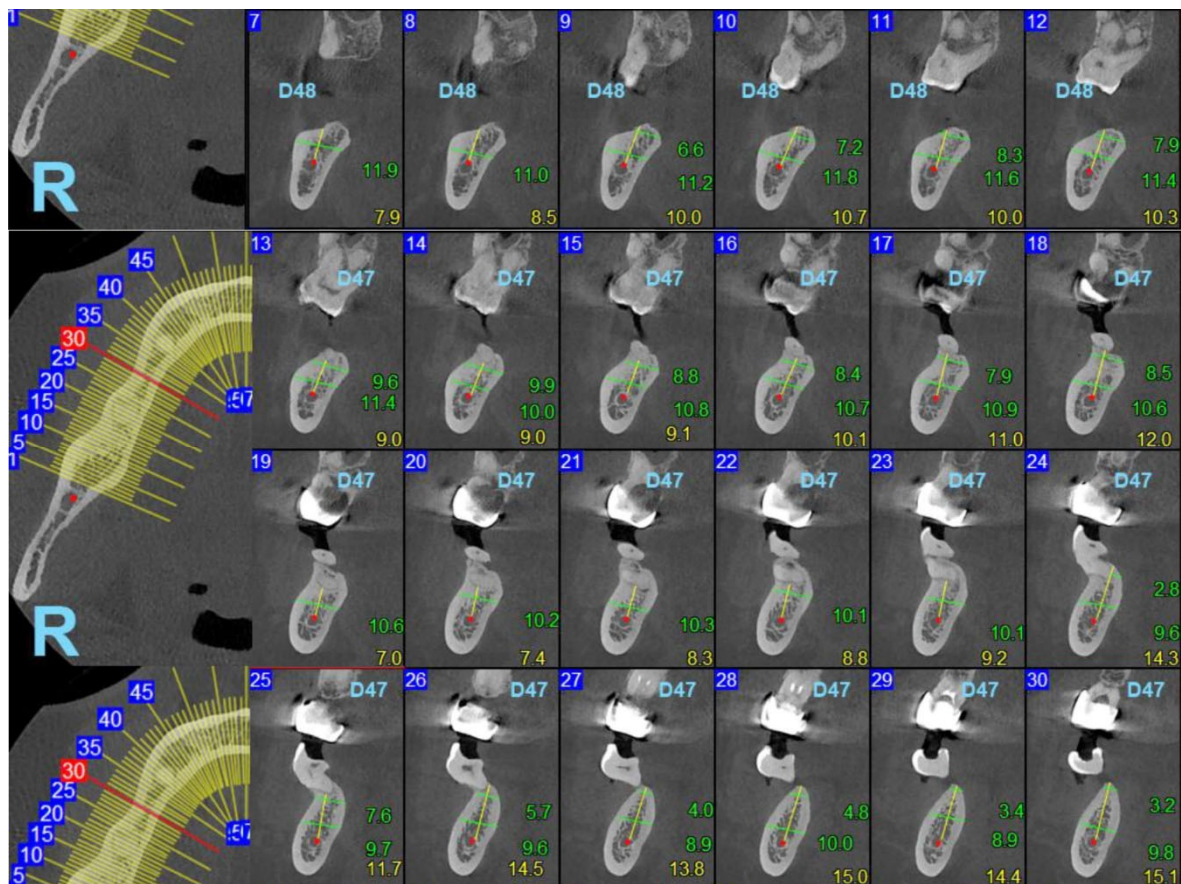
CBCT cross sections, showing the mesialized position of the third molar, in front of the retromolar triangle (slices 1–12), occupying the second and first molars' place (images beginning with slice 13), and the horizontal position of its roots, which exclude a potential root canal treatment. The mesial root, which is the deepest, is situated in the bone, but always above the canal lumen, while the distal root is having contact with the bone only on its lower face; there is no root septum. CBCT: Cone-beam computed tomography; R: Right.
